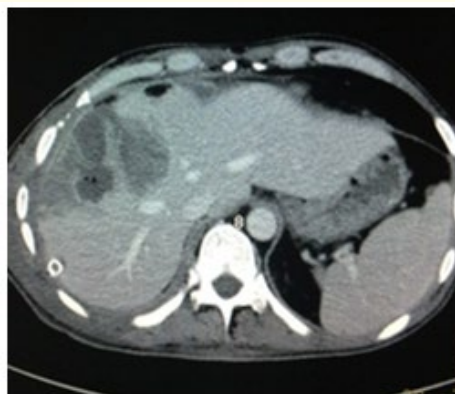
Angio CT scan after right hepatic artery ligation.
